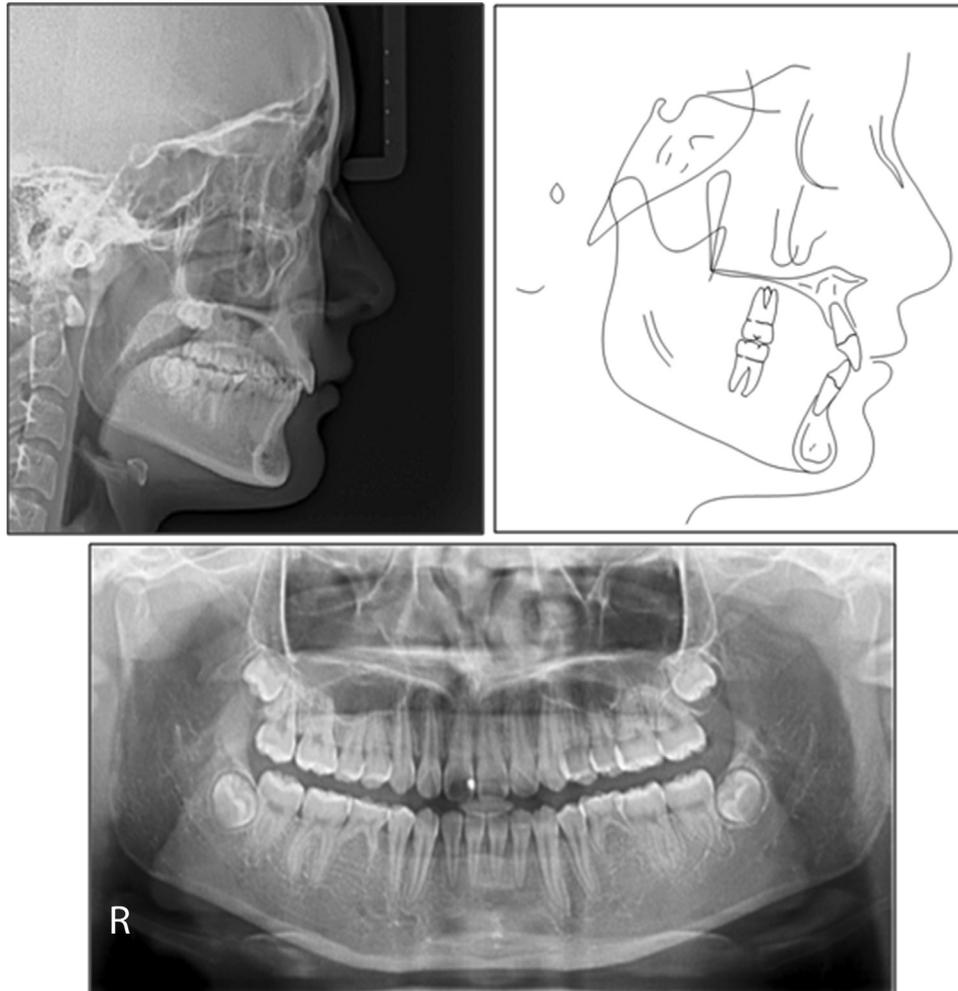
Posttreatment lateral cephalometric and panoramic radiographs.
